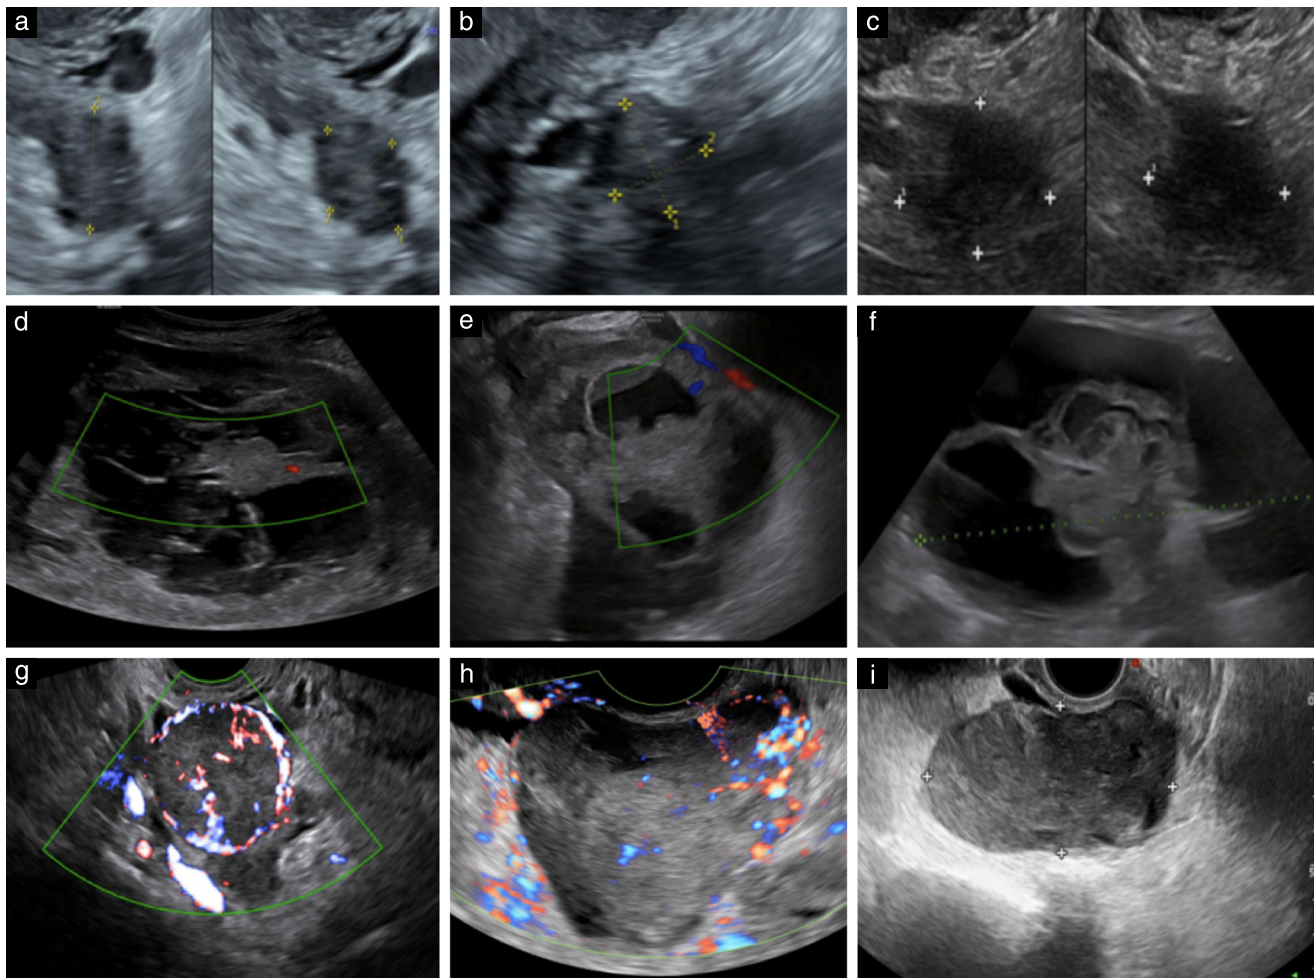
Ultrasound images of ovarian metastasis in patients with endometrial cancer metastatic to ovary. On ultrasound, ovaries appeared normal (a–c) or as having multilocular-solid (d–f) or solid (g–i) mass.
